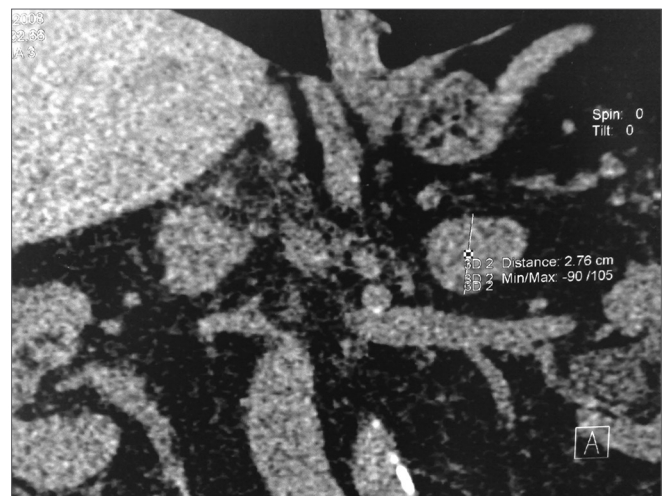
Preoperative CT scan at adrenalectomy showing left and right adrenal tumors.
